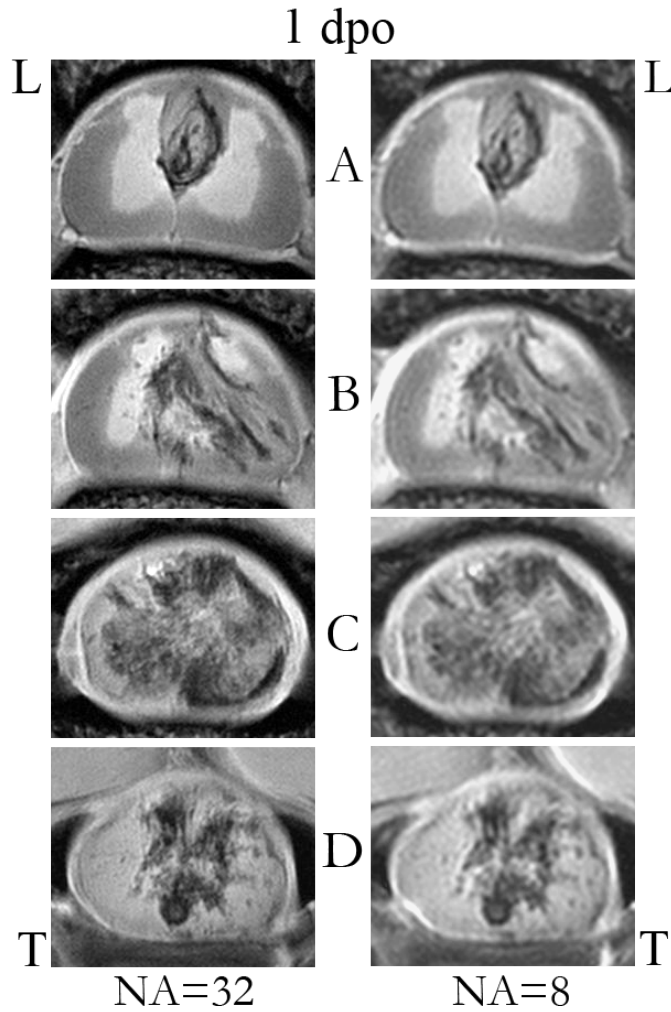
Comparison of the highest resolution (PD, NA=32) to a lower resolution (PD, NA=8). MRI sections are the same as in figure 4.16 page 94. Acquisition time was 8-10 hours for NA=32 and 50 minutes for NA=8. Resolution was $37.8 \times 37.8 \mu m^2$ for NA=32 and $68 \times 68 \mu m^2$ for NA=8.
